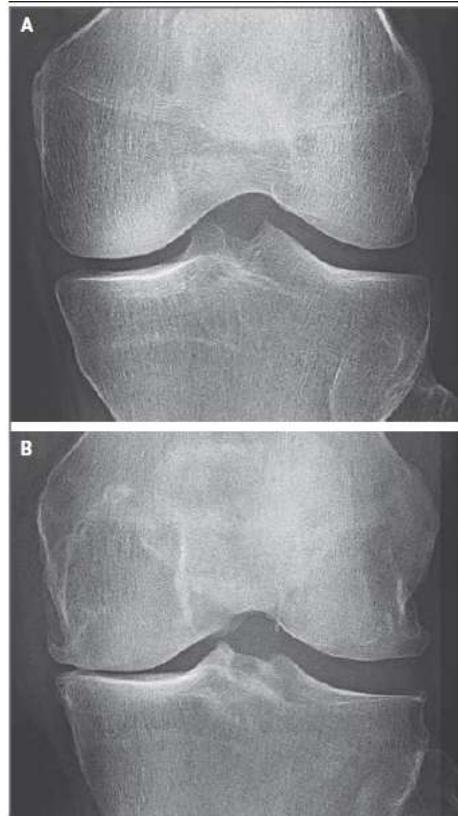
Radiographic image of a knee for assessment of osteoarthritis. (A) A radiographic image of a normal knee. (B) A radiographic image of an osteoarthritic knee with joint space narrowing, subchondral sclerosis, and marginal osteophytes. Reproduced with permission from Sharma, L, *Osteoarthritis of the Knee*. N Engl J Med, 2021. 384: p. 51-59, Copyright Massachusetts Medical Society.
